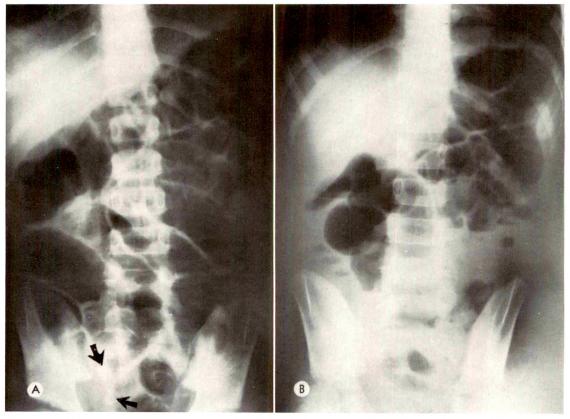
(A) A supine roentgenogram of the abdomen demonstrates two appendicoliths with associated distended loops of small bowel. (B) Erect roentgenogram of the same patient demonstrates distended loops of small bowel with differential fluid levels consistent with mechanical small bowel obstruction. This is secondary to an appendiceal abscess.
